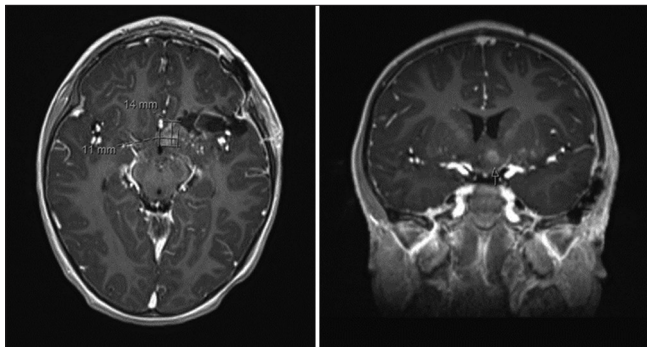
6-week postoperative magnetic resonance imaging demonstrating an ill-defined enhancement in the left subcallosal region at the deep posterior margin of the resection cavity consistent with a residual tumor.
